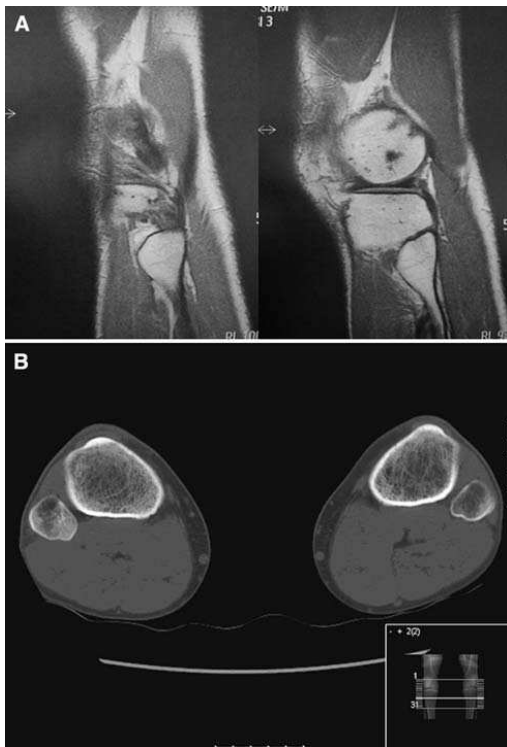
MRI and CT scan of left knee 8 months after injury A MRI indicating a subtle irregularity of the anterior proximal tibiofibular joint and minor effusion. B CT scan of left knee demonstrating a minimal anteriorly displaced fibula head
